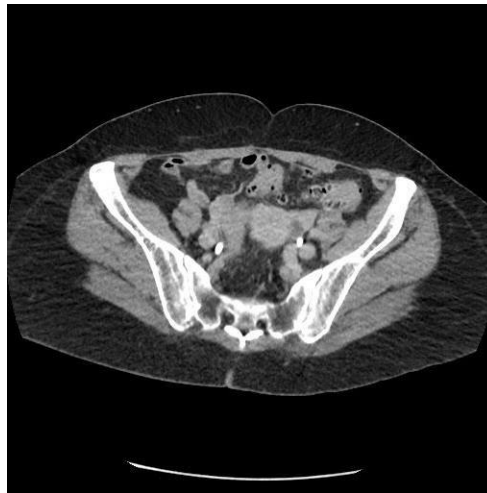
CT of the abdomen in portal phase, sagittal section, thickening and diverticula in the rectosigmoid.
